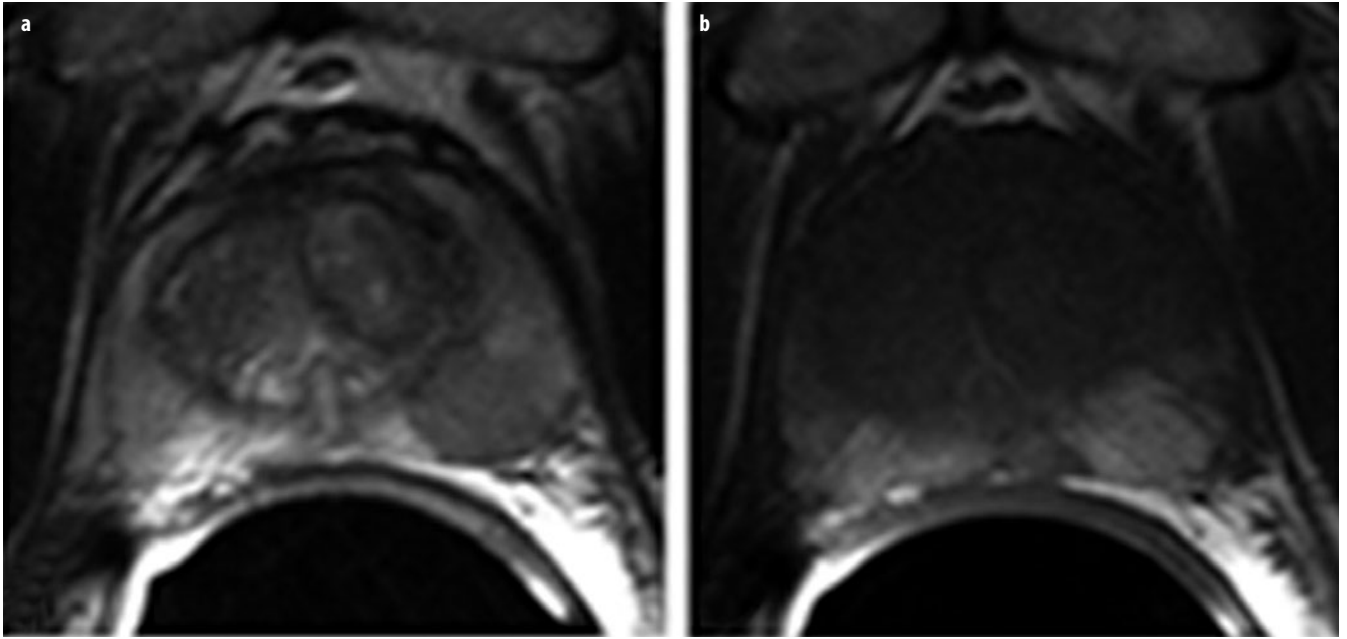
a, b. Postpuncture bleeding. a Bleeding can be mistaken for prostate cancer in T2-weighted turbo-spin-echo magnetic resonance imaging (TSE-MRI) due to its hypointense appearance. b Hyperintense postpuncture hemorrhagic changes can be detected on both sides in the peripheral zone in the corresponding axial T1-weighted TSE slice
